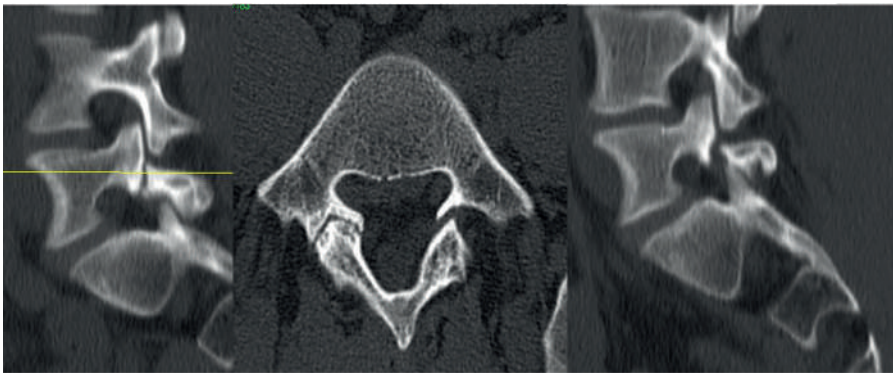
Bilateral pars interarticularis defects demonstrated on CT. Multiplanar computed tomography images of the lumbar spine demonstrating bilateral defects of the pars interarticularis at the L5 level. The left and right sagittal reconstructions show cortical discontinuity of the pars regions, while the axial image confirms bilateral involvement of the posterior elements. These findings are consistent with bilateral isthmic spondylolysis.
